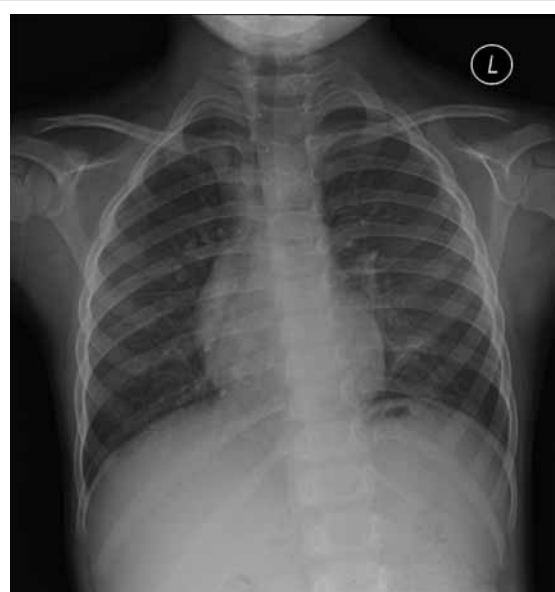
A chest X-ray performed after 3 months of prednisolone therapy showing improvement in reticulonodular densities
